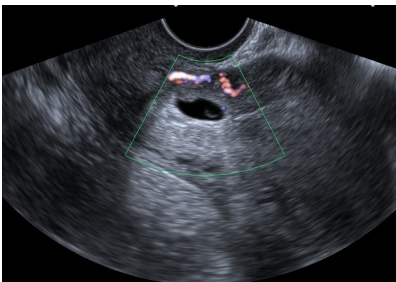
"+++" Color Doppler blood supply; intense peripheral blood
